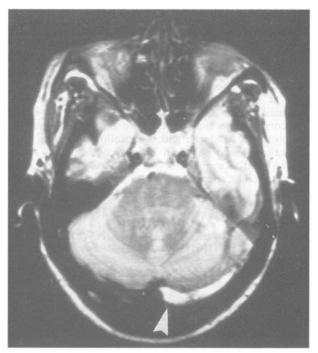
MRI with gadolinium (axial cut) showing left transverse sinus thrombosis (arrow).
